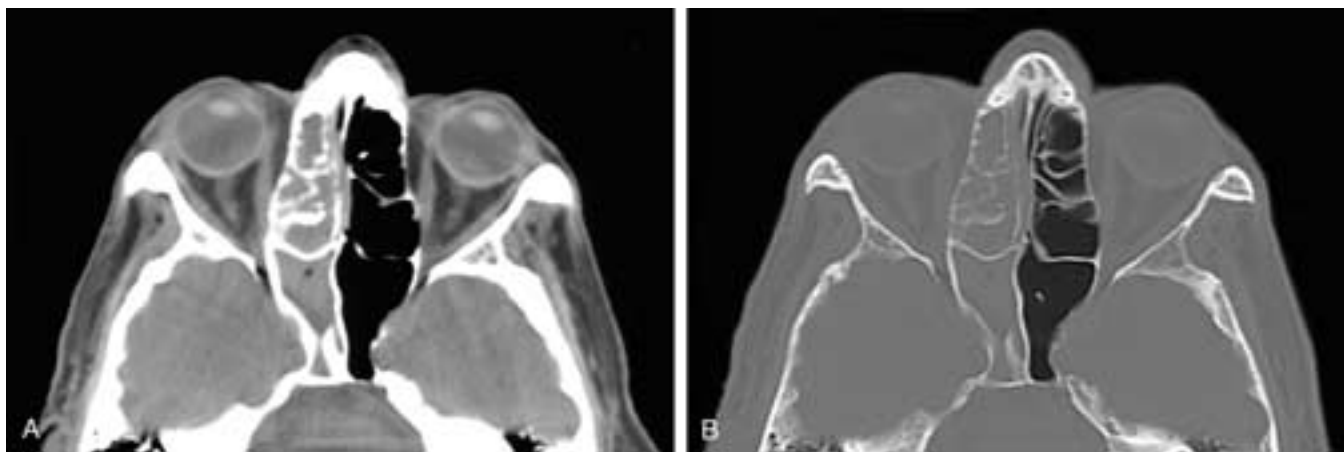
A, Axial CT scan through the ethmoid and sphenoid sinuses viewed at narrow "soft-tissue" window settings shows opacification of these sinuses, with apparent sclerosis and thickening of the surrounding bone and ethmoid septae. B, Same image viewed at wide "bone" window settings shows that the bones are not sclerotic and thickened. The wide window views of the bone most closely reflect the actual bony changes.
